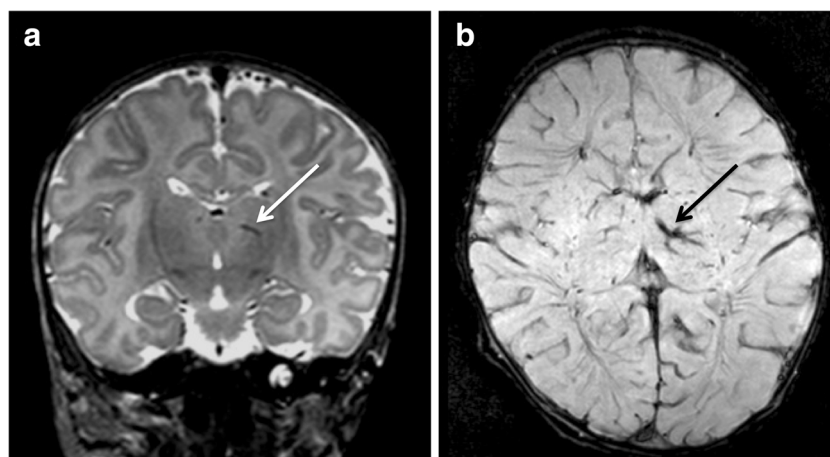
a Coronal T2-weighted and b axial susceptibility-weighted image of case 12 showing the relatively uncommon localization of a DVA (*arrow*) in the left thalamus
